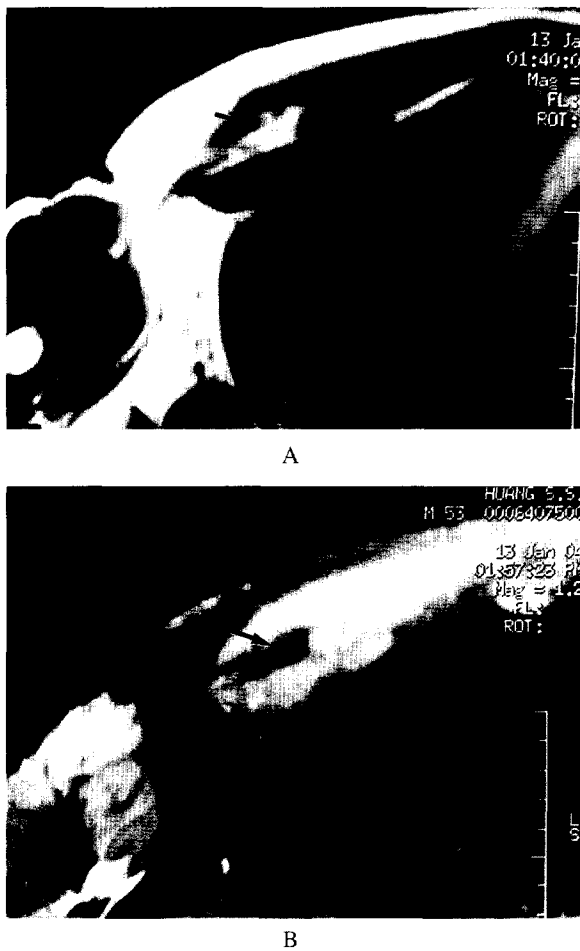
Post-operative MR image shows focal fatty changes in the muscle over the repair region. (A) T1-weighted image shows a focal hyperintense shadow (arrow) in the right pectoralis muscle near the repair region. (B) Fat-saturation T2-weighted image shows a hypointense shadow (arrow) in the right pectoralis muscle near the repair region.
